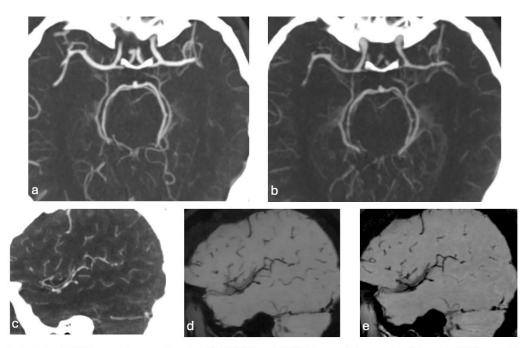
CTA brain (a, b (axial MIPs one day apart), c (sagittal MIP)) and MRA intracranial vessel wall imaging (d (pre-contrast MinIP), e (post-contrast MinIP)) were performed. The dynamic nature of the process is demonstrated by the rapid onset of multifocal stenoses in the anterior and posterior circulation after one day (a, b). In an area of multifocal left MCA narrowing (c), there was no associated abnormal enhancement (d, e).
